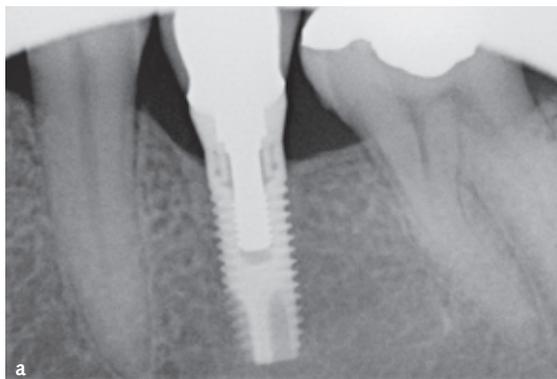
Grafted compared to control implant: periapical radiograph taken 1 year after loading of the grafted implant (a) and control implant (b).
